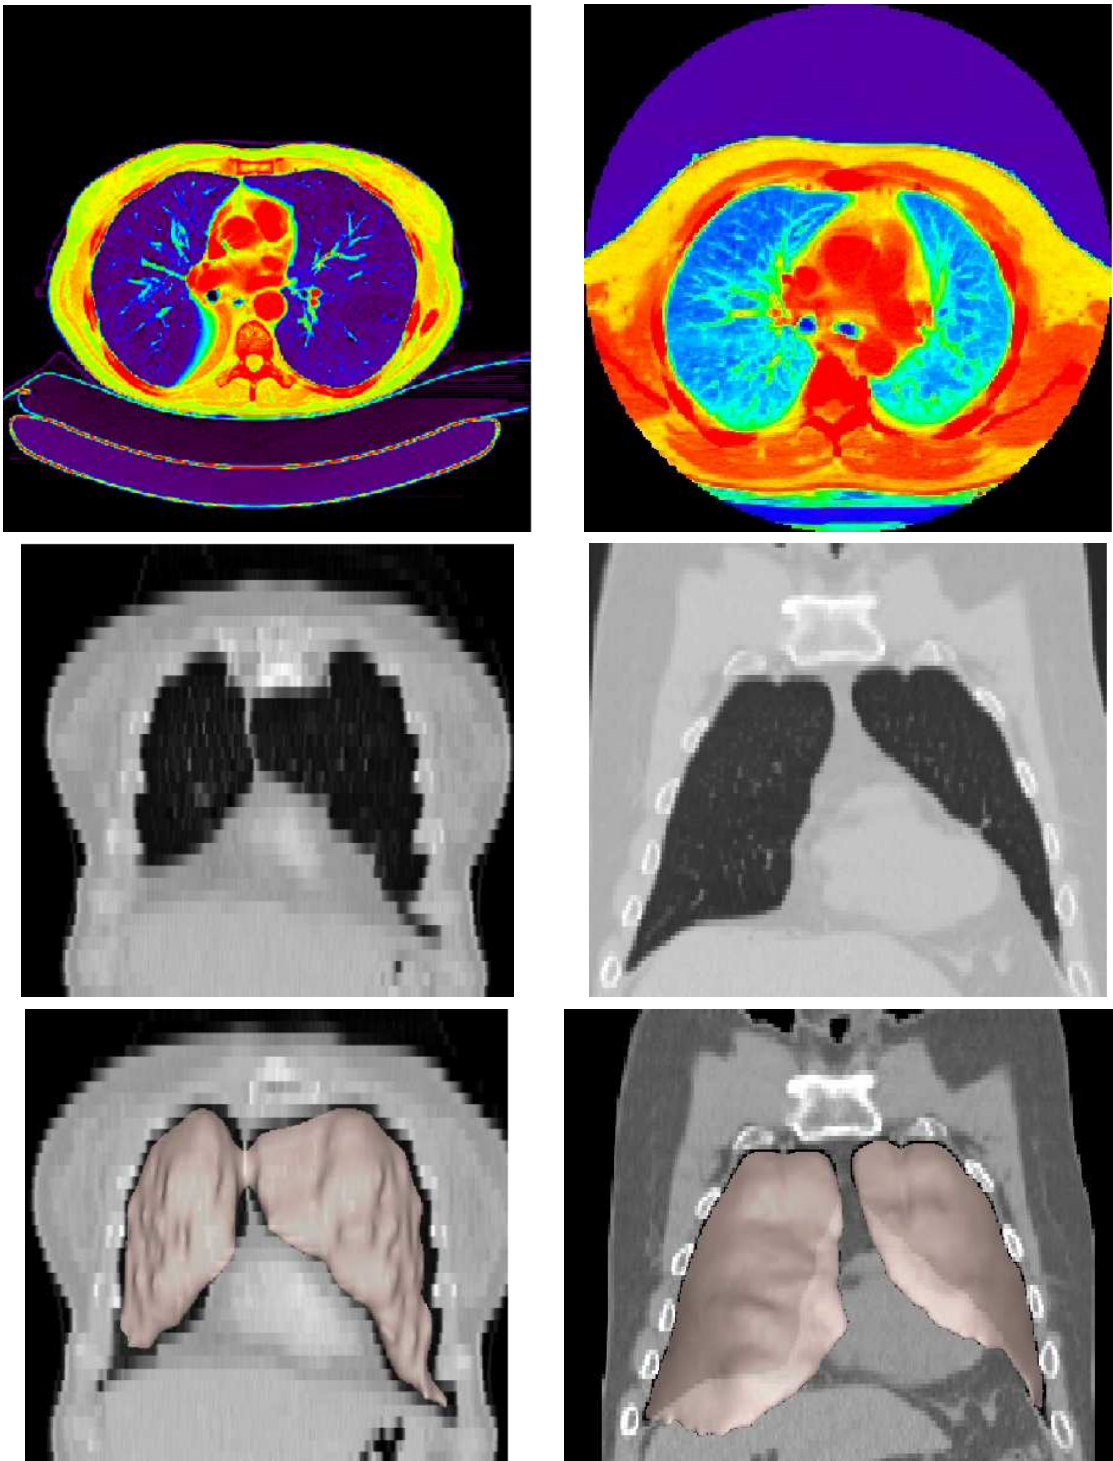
Ambiguities solved by consistency verification checks. Top: Presence or absence of a circle limiting the FOV of the CT image. Middle and bottom: low (left) and high (right) resolution CT images with joint (left) or separated (right) lungs, leading to the selection of one or two connected components in the segmentation procedure. The 3D rendered segmented lungs are shown in the bottom images.
